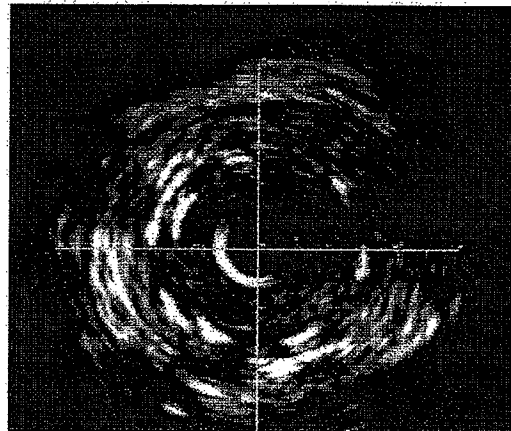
Example of a black hole (left) after implantation of a sirolimus-eluting stent, as detected by intravascular ultrasound (IVUS). The black hole has a homogeneous black appearance, but its differentiation from the lumen requires careful evaluation of the IVUS image. The typical IVUS appearance of intimal hyperplasia is shown after implantation of a bare metal stent (right).
